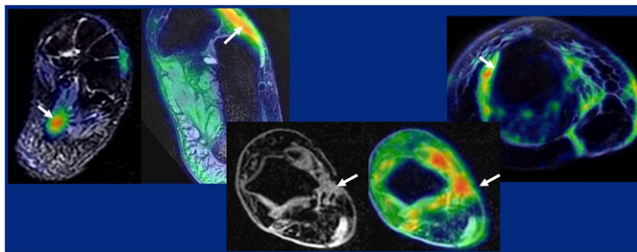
Musculoskeletal changes in complex regional pain syndrome (CRPS) of the foot on ^{18}F -FDG PET/MR imaging. Focally high uptake was seen in (left to right): foot muscle, neurovascular bundles, and skin and subcutaneous tissue. PET detected more abnormalities than MR imaging. ^{18}F -FDG PET may be more sensitive to earlier CRPS changes than MR, before the onset of irreversible muscle or skin atrophy.
